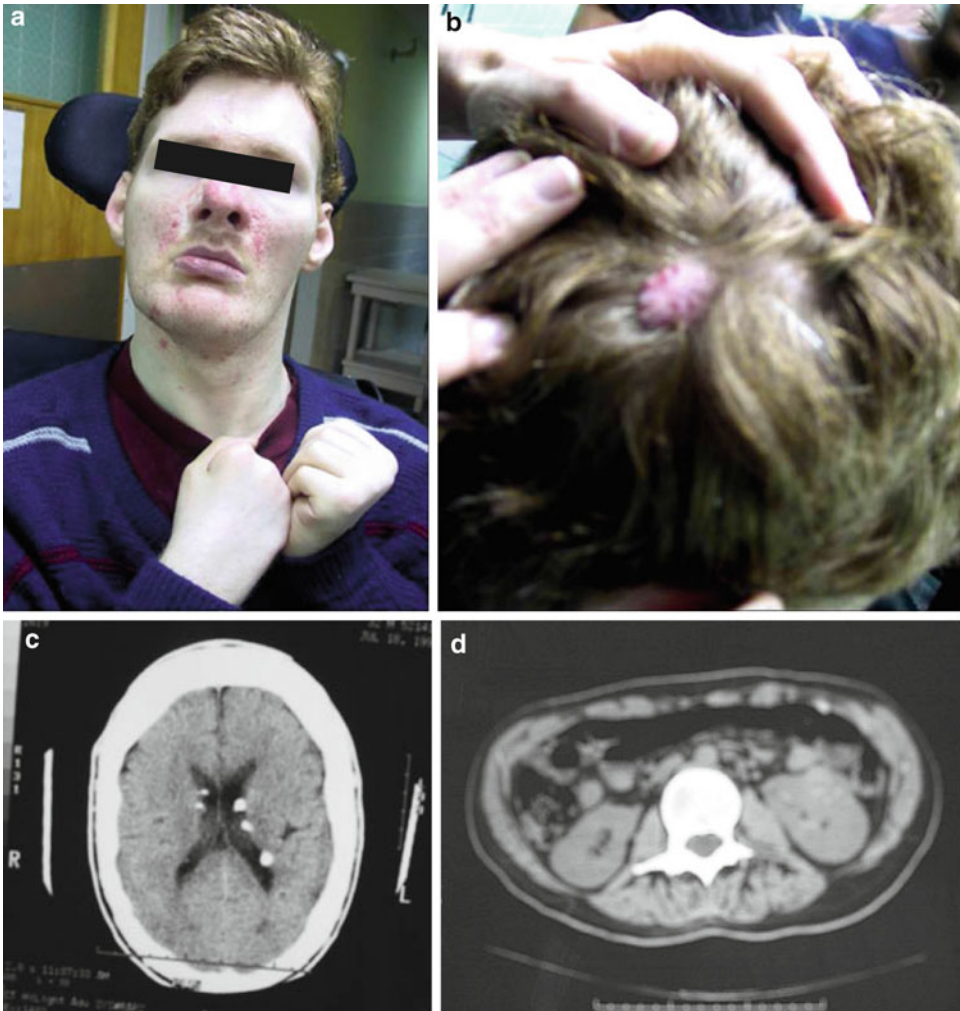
(a–d) An adult with tuberous sclerosis showing typical facial angiofibromas and a scalp plaque. CT of the brain showed presence of calcified subependymal nodules.
